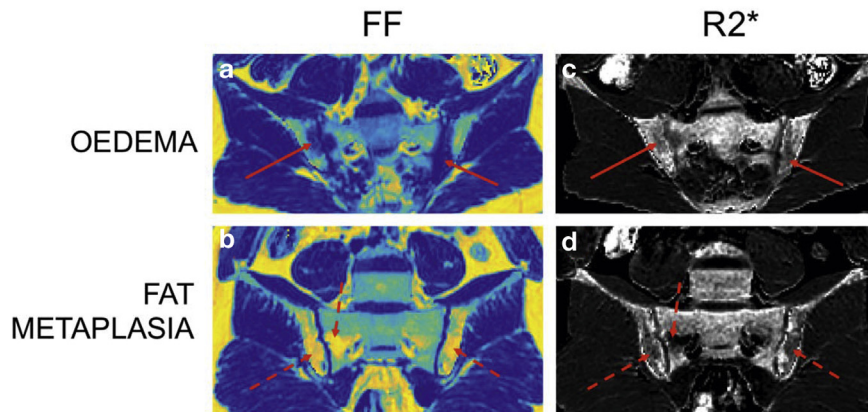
Chemical-shift encoding MRI in spondyloarthritis: fat fraction (FF) and R2* images showing areas of bone marrow oedema (solid arrows) versus fat metaplasia (dash arrows). R2* represents the rate of transverse magnetization decay, and has been proposed as a marker for bone mineral loss/osteoporosis. FF values are reduced in areas of bone marrow oedema (a), but increased in areas of fat metaplasia (b). R2* measurements are slightly reduced in areas of bone marrow oedema (c) and markedly reduced in areas of fat metaplasia (d), which may be due to local osteoporosis. Image courtesy of Dr TJP Bray, UCLH, London.
